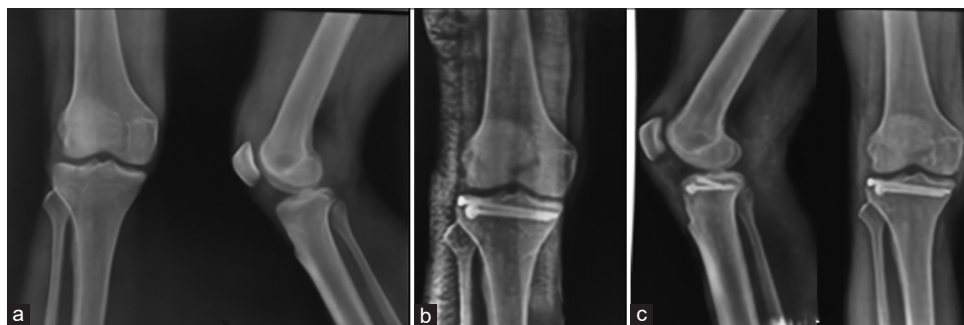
Series of radiographs showing Schatzker type 1 fracture and its fixation using 2 cancellous cortical screws. (a) Schatzker type 1 fracture, (b) immediate postoperative X-ray on day 1, (c) union at 6 months follow-up
